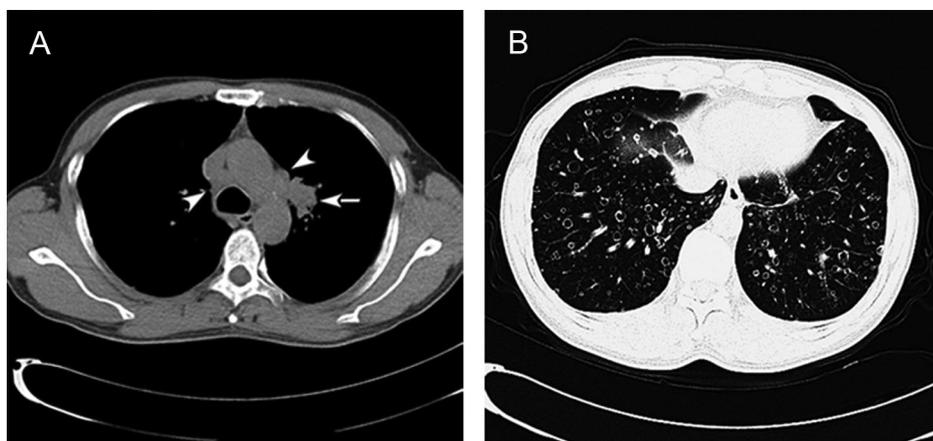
A, Repeated chest computed tomography after 1 month duration revealed enlarged mass at 35×30 mm. B, Rapidly enlarged, widespread, disseminated thin-walled cystic lesions in bilateral lungs.
